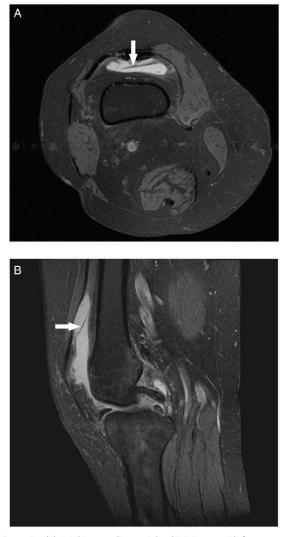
(A) Axial intermediate-weighted MR image with fat suppression shows a suprapatellar plica (arrow) as a band-like stricture of low signal intensity at the suprapatellar pouch, which is filled with fluid. (B) Sagittal intermediate-weighted MR image with fat suppression shows a floating low-signal suprapatellar plica (arrow), which is depicted adequately because of the presence of fluid in the suprapatellar pouch.
